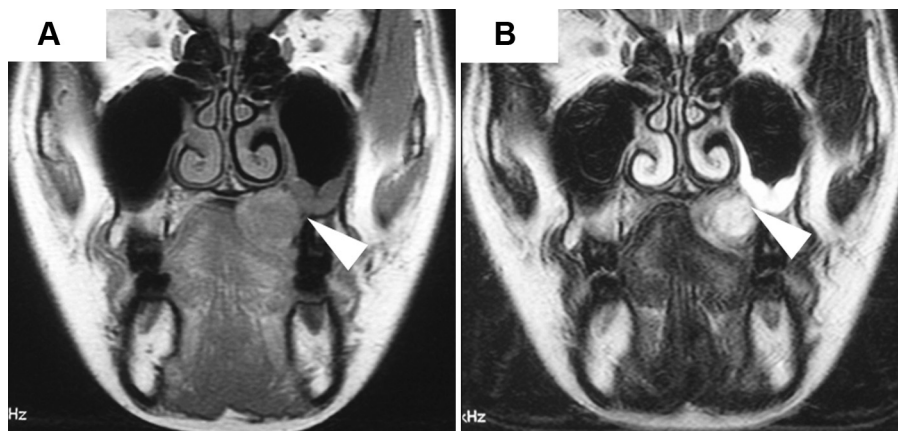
The enhanced T1-weighted (A) and T2-weighted (B) coronal images demonstrated diffuse enhancement in left hard palate. Arrows: the bone resorption at the hard palate.
